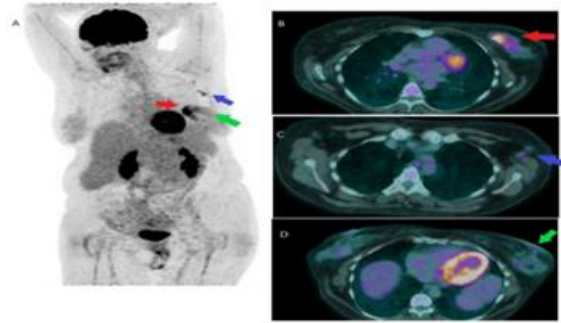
(PET/CT Brest Cancer)
